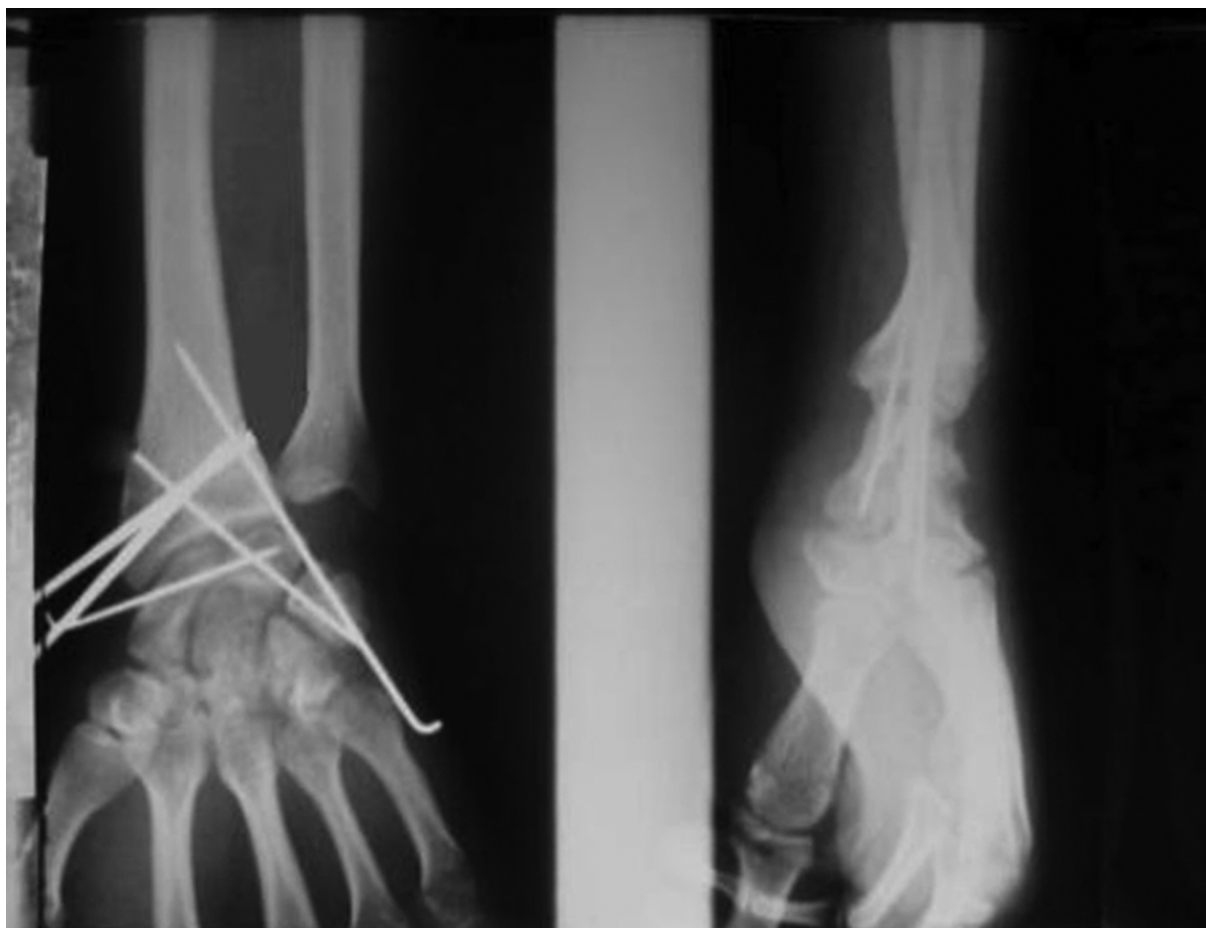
Postoperative Radiographs
